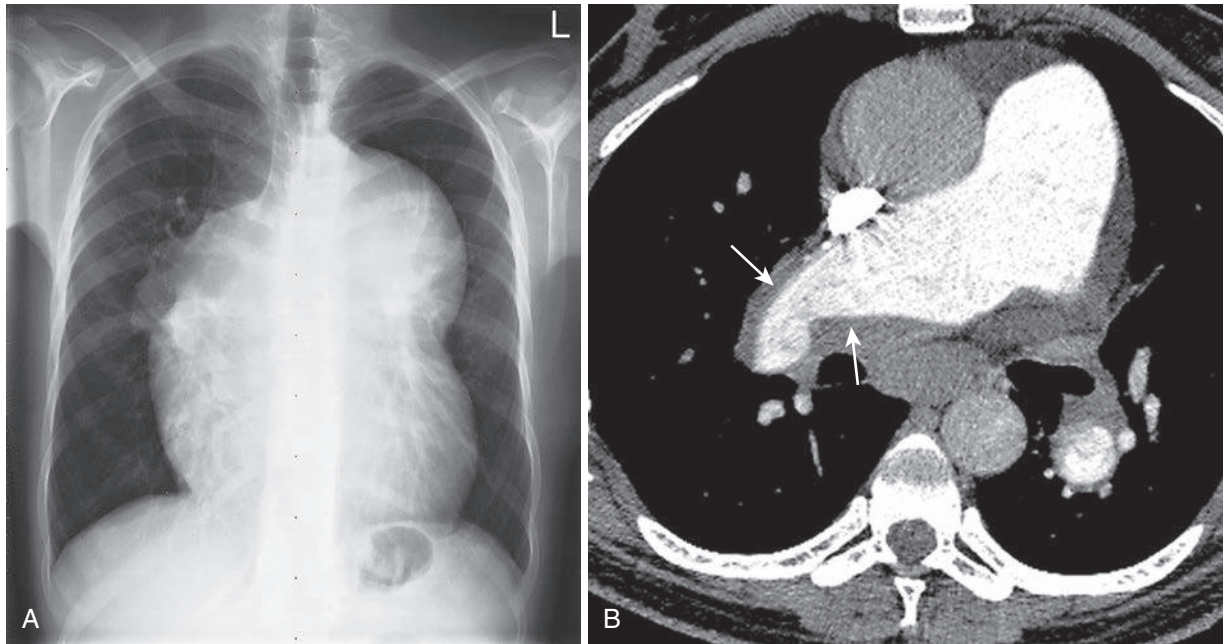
A, Giant pulmonary artery aneurysm in an 18-year-old man with nonrestrictive, perimembranous, and multiple muscular ventricular septal defects and Eisenmenger syndrome. Chest radiograph shows an aneurysm of the pulmonary trunk, dilation of the central right and left pulmonary arteries, and pulmonary artery branch narrowing toward the periphery of the lungs. The heart is grossly enlarged (cardiothoracic ratio 0.67). B, Laminated thrombus in the proximal right pulmonary artery in a 40-year-old man with nonrestrictive patent ductus arteriosus (arrows). (A, Courtesy B. Marincek, Institute of Diagnostic Radiology, University Hospital, Zurich, Switzerland.)
